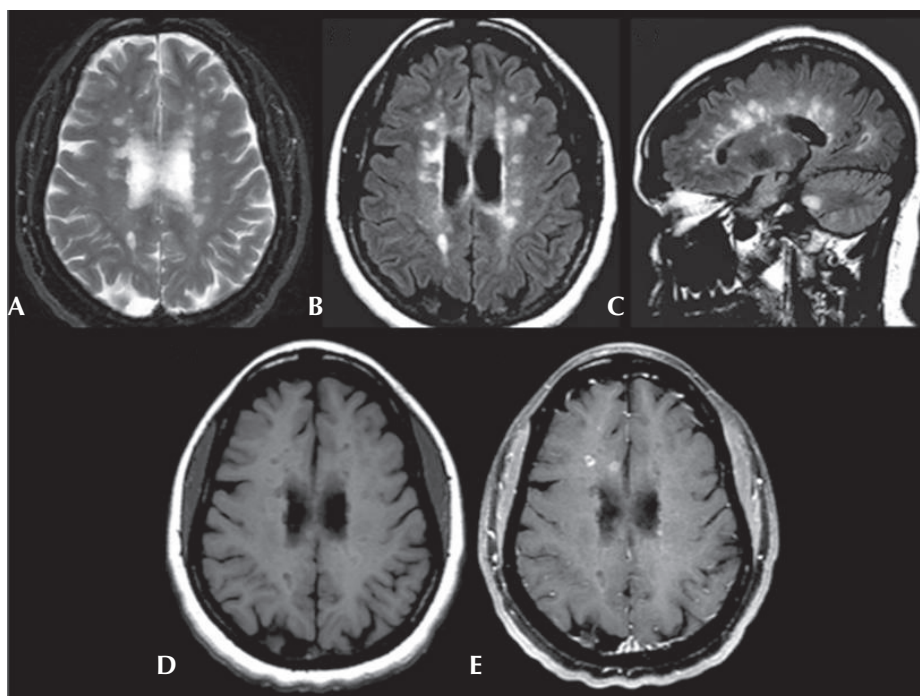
Axial T2-weighted (A) and axial fluid-attenuated inversion recovery (FLAIR) (B) images show multiple, ovoid shaped, hyperintense foci in the periventricular area, consistent with multiple sclerosis plaques. Sagittal FLAIR (C) image also shows these lesions to be radiating out from the corpus callosum. Axial precontrast T1-weighted (D) image shows that many of these lesions are hypointense, consistent with black holes. Axial postgadolinium fat saturated T1-weighted (E) image shows that some of these plaques enhance in a ring-like fashion consistent with active plaques.
